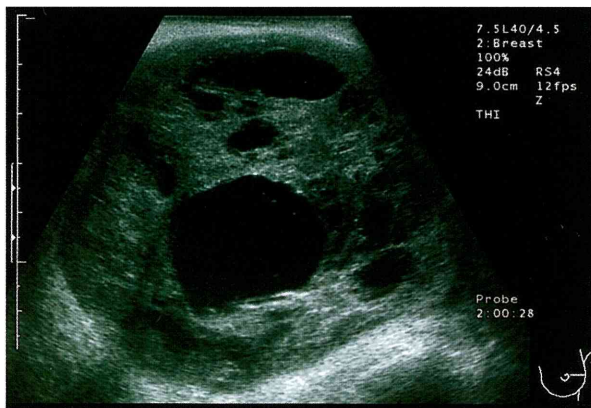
Ultrasonography showed a well-defined heterogeneous hypoechoic lesion. The tumor, approximately 10 cm in diameter, consisted of groups of multiple nodules with cystic changes. Vascular signals were scanty.
